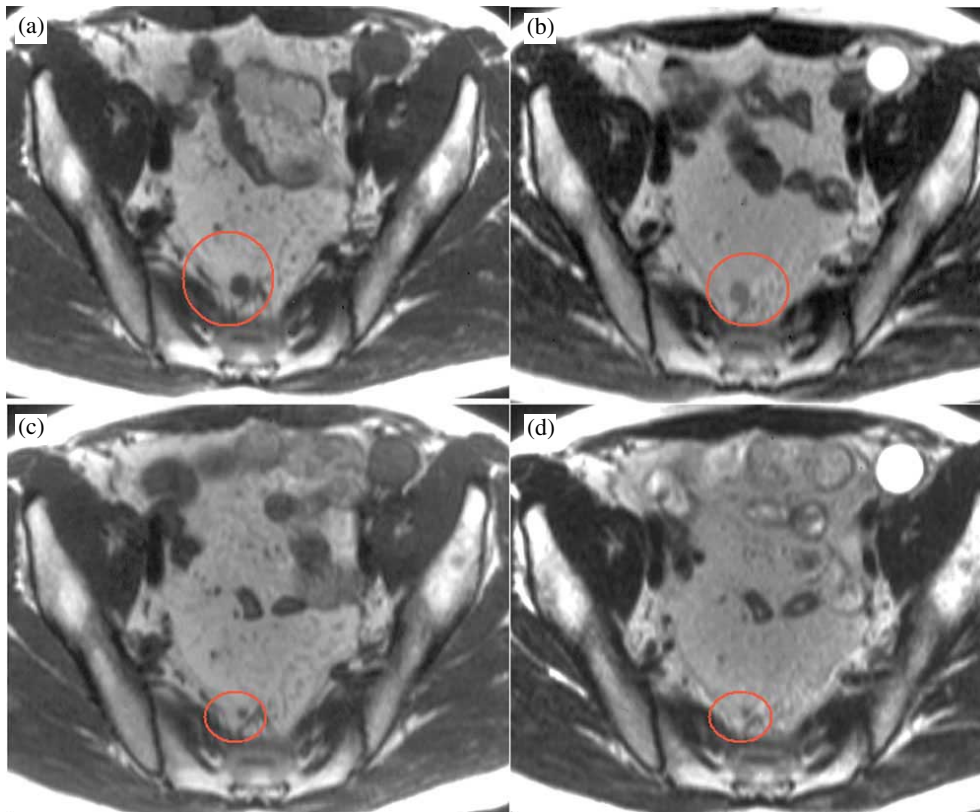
Prostate cancer. (a) & (b) T1 and T2-weighted images prior to radiotherapy showing a 1 cm presacral lymph node. (c) & (d) The same patient post-treatment. The lymph node has regressed considerably during treatment demonstrating response to radiotherapy.
